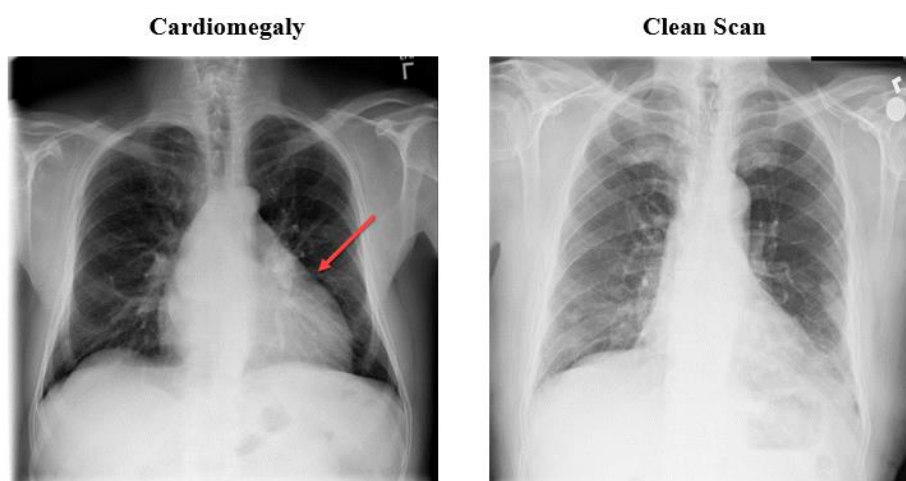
Side by side comparison of thoracic cavity x-ray scans
